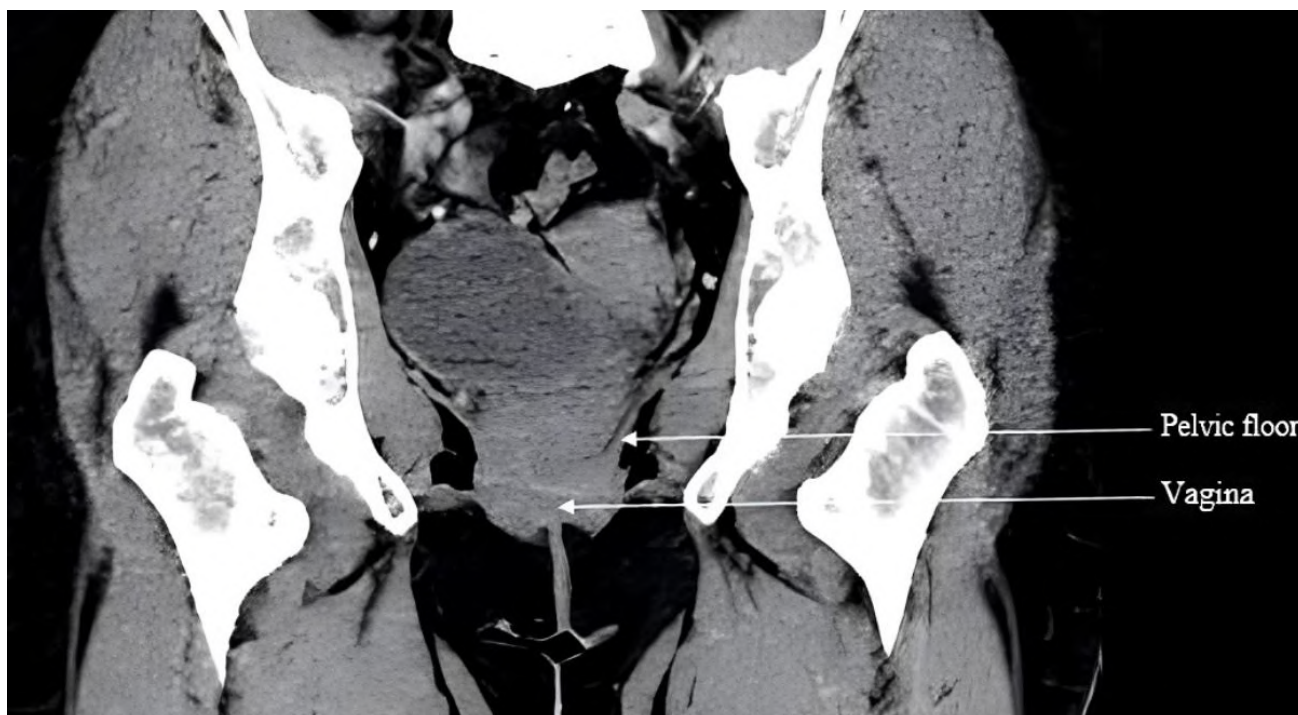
Coronal section of computerised tomography (CT) scan showing pelvic floor muscle at the level of the vagina.
